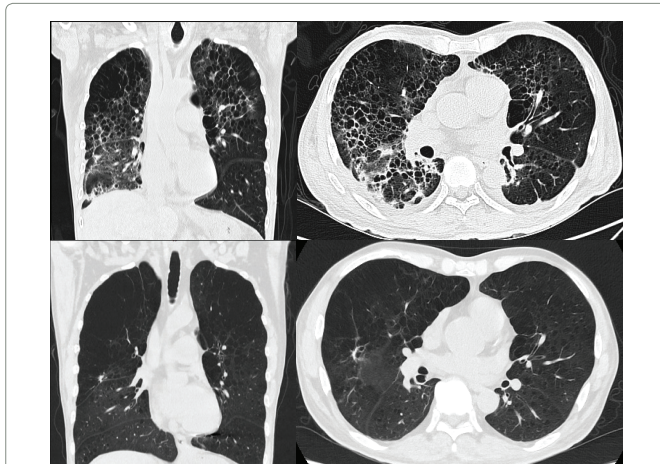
Comparison of High-Resolution Computed Tomography (HRCT) Images Before and After Treatment A) High-resolution computed tomography revealed patchy consolidation, thickening of interstitial lines, pulmonary emphysema, a honeycomb pattern in both lungs, and patchy consolidation in the right lower lobe initially. B) Some focal nodular opacity was observed in the right upper lung, along with bilateral emphysema after finishing treatment.
